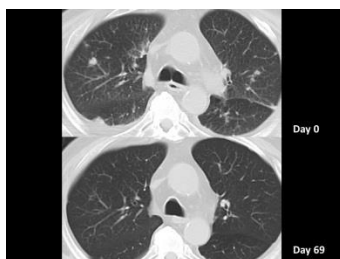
Whole-body computed tomography (CT) findings for the present case. CT to detect the septic focus revealed multiple small nodular lesions in the bilateral lung fields (upper: pre-treatment, lower: post-treatment)
